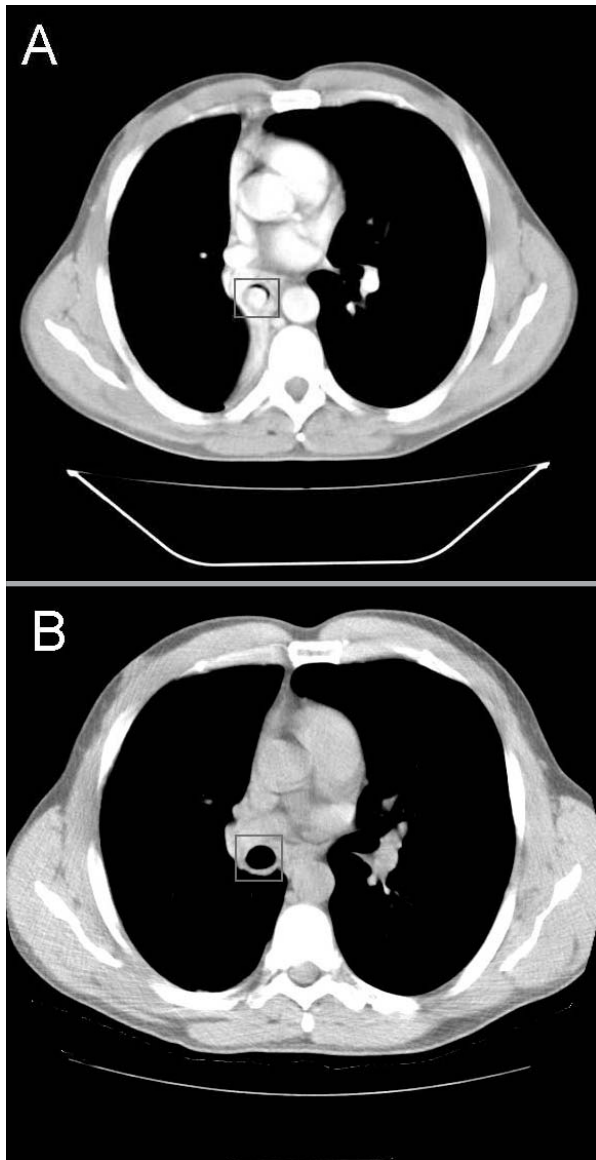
Preoperative chest CT (A) disclosed an endobronchial mass, which arose from the origin of the right main bronchus and grew distally in the truncus intermedius and lower lobe bronchus; postoperative chest CT (B) revealed a normal endobronchial appearance with secondary complete resolution of the atelectasis of the lower lobe.
